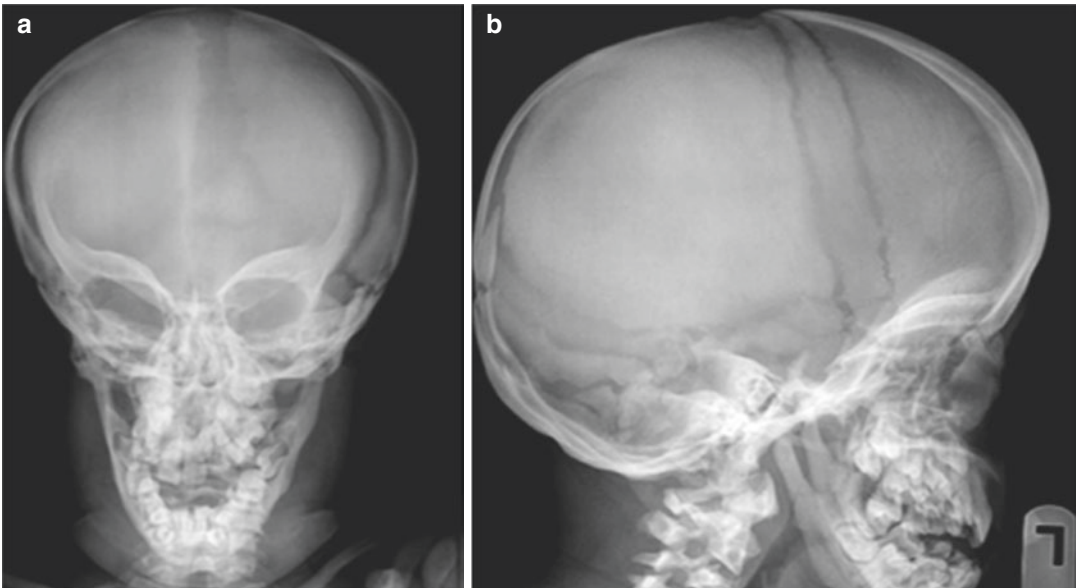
Pyknodysostosis. (a) Frontal and (b) lateral skull radiographs show widened sutures and wormian bones, apart from osteosclerosis (Courtesy of Dr. Mark Holland with permission from Radiopaedia.org)
